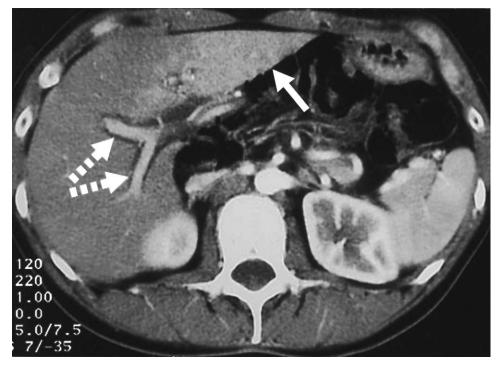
Contrast-enhanced CT in arterial phase showing the portal vein stretched, displaced forward, and narrowed because of an ab extrinseco compression due to the transverse colon herniated through the Winslow's foramen. The arterial dominant phase shows a transient hepatic attenuation difference (THAD) involving the lateral segments (i.e., segments II and III) of the left lobe (white arrow), with good evidence of flow through the left hepatic artery. A circumferential hypodensity "halo" is present around the peripheral branches of the portal vein (dotted line arrows), a sign of portal venous narrowing.
